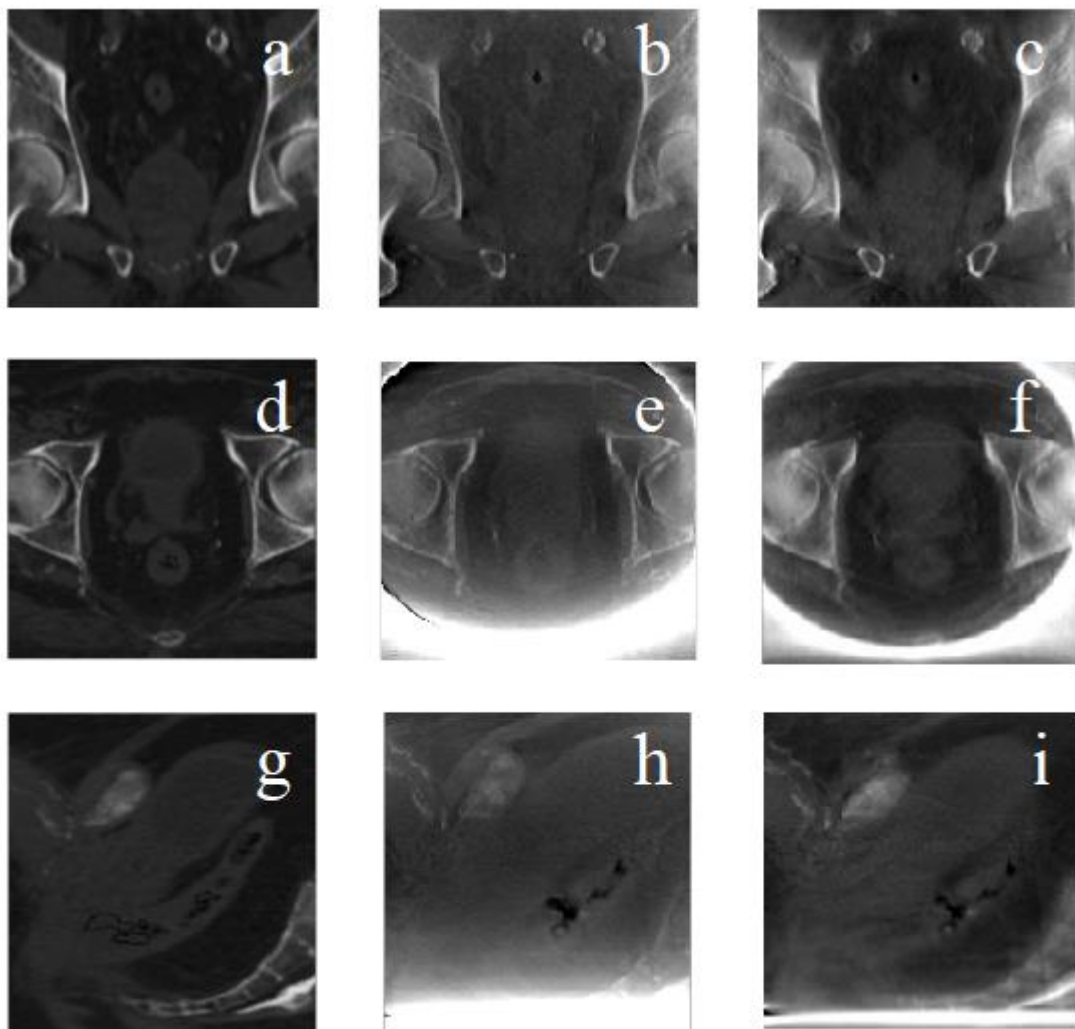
Sample correction. (a), (d), (g) are the virtual CT views; (b), (e) and (h) are the original CBCT; (c), (f) and (i) represent the corrected CBCT.
